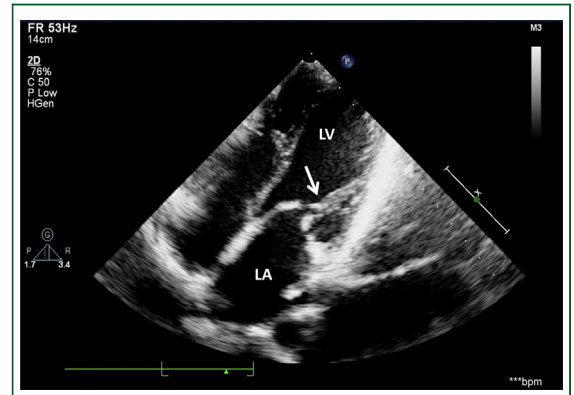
Apical 4-chamber view showing thickened mitral leaflets with restricted opening and severe subvalvular deformity (arrow). Abbreviations as in Figure 1.
